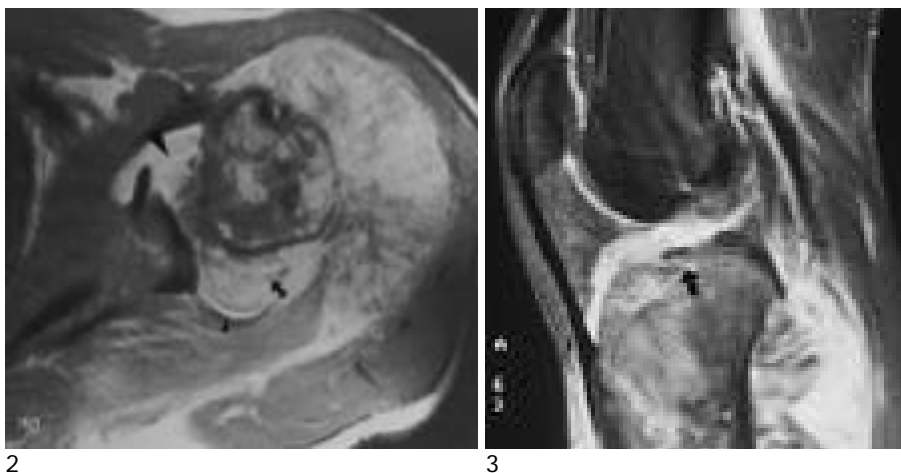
A 20-year-old man with osteosarcoma in the proximal humerus. Axial T2-weighted image shows mass in the synovial cavity (arrows). The mass revealed extrasynovial mass which displaces synovial cavity pathologically. Arrowhead indicates joint effusion. Fig. 3. A 16-year-old boy with osteosarcoma in the proximal tibia. Enhanced sagittal image shows disruption of cortical bone at articular portion (arrow). Pathologic examination confirmed cortical erosion, but no involvement of joint was found.
